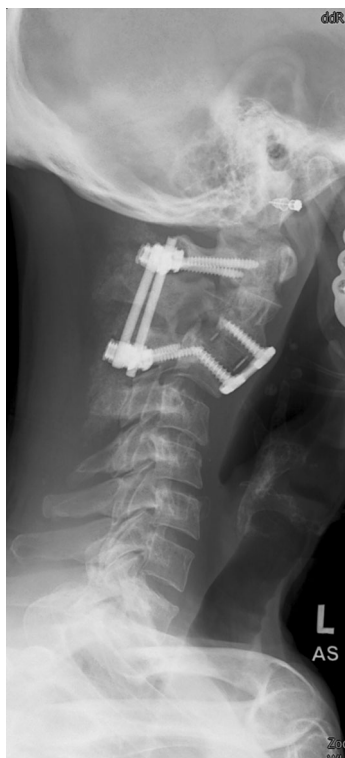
Radiographs at 6-month follow-up revealed good placement of all implants with good reduction and maintenance of reduction at C2–C3 level
